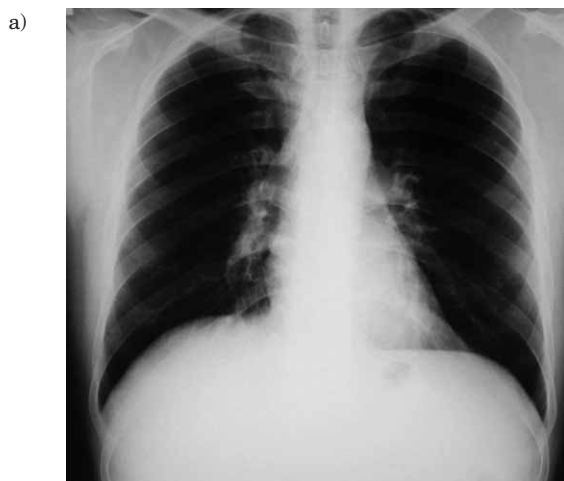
An x-ray of the thorax demonstrated bihilar lymphadenopathy. a) AP, b) lateral.
